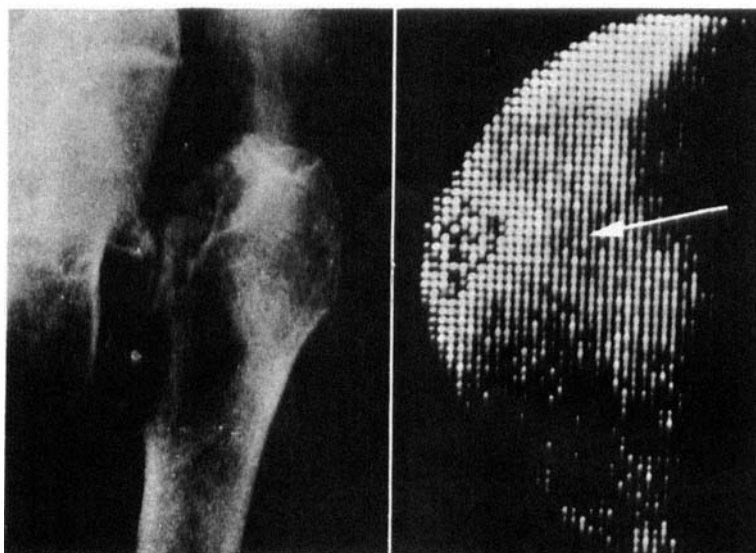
Intracapsular neck fracture with moderate dislocation. The scintigram shows normal and uniform radioactivity over the femoral head region.
